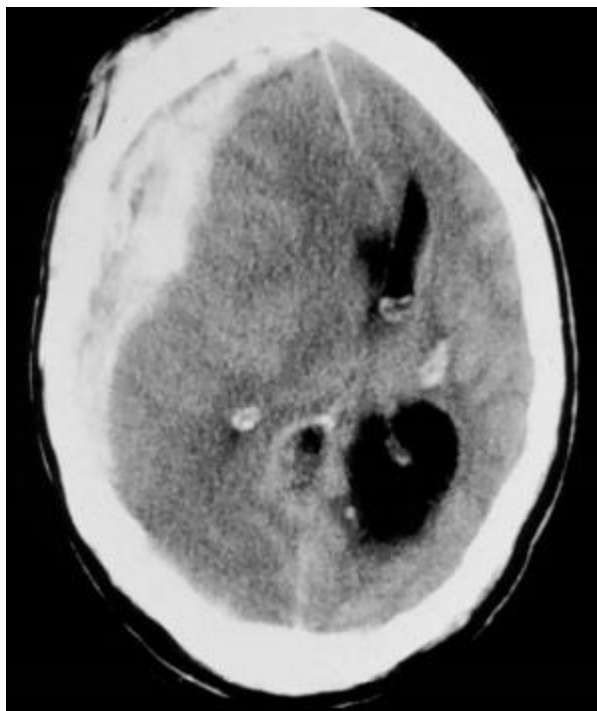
CT appearance of subdural haematoma, associated with mid-line shift
